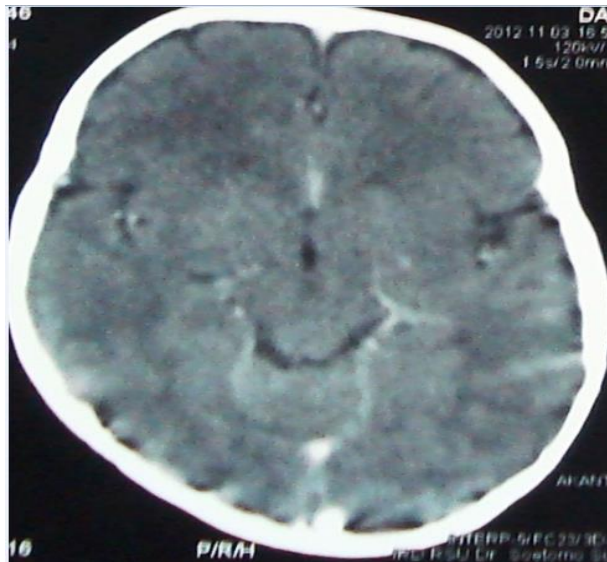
Head CT Scan showing cerebral edema and encephalitis
